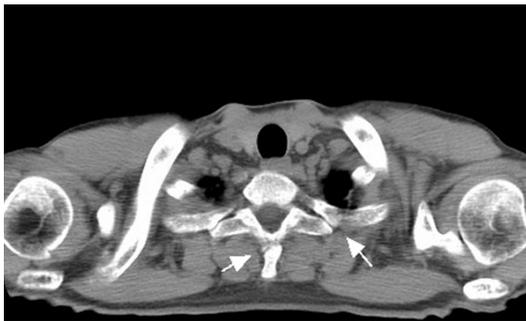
Chest computed tomography shows fracture deformities of T1 and the left rib (arrow).
